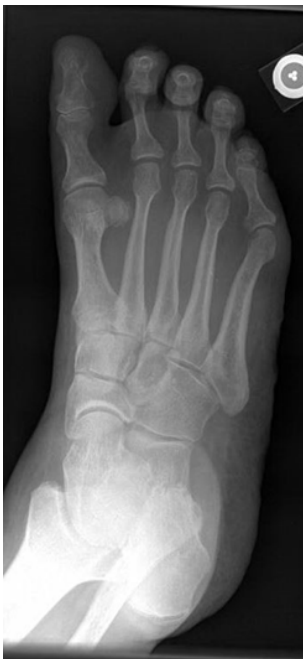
X-ray oblique view right foot.
